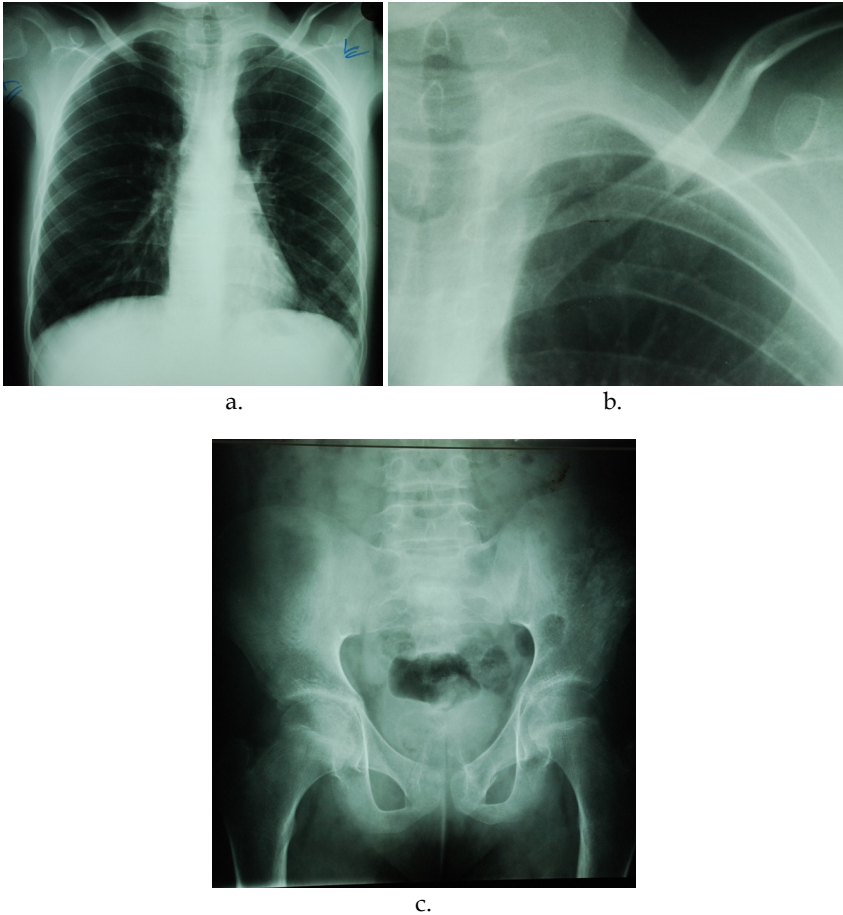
a.,b.,c. Case 1. A 17-year-old teenager with known dermatomyositis was referred for chest and pelvis radiographs. There is slight left based patchy opacification. Furthermore there is a minimal linear calcification of the left side of the neck (Fig. 1a,b). (Fig. 1b is a magnified image to demonstrate the calcification). The AP pelvis X-ray demonstrates extensive linear plaque-like calcification overlying the outer aspect of the left iliac bone (Fig. 1c). The radiological features correlate exactly with the clinical diagnosis of dermatomyositis.
